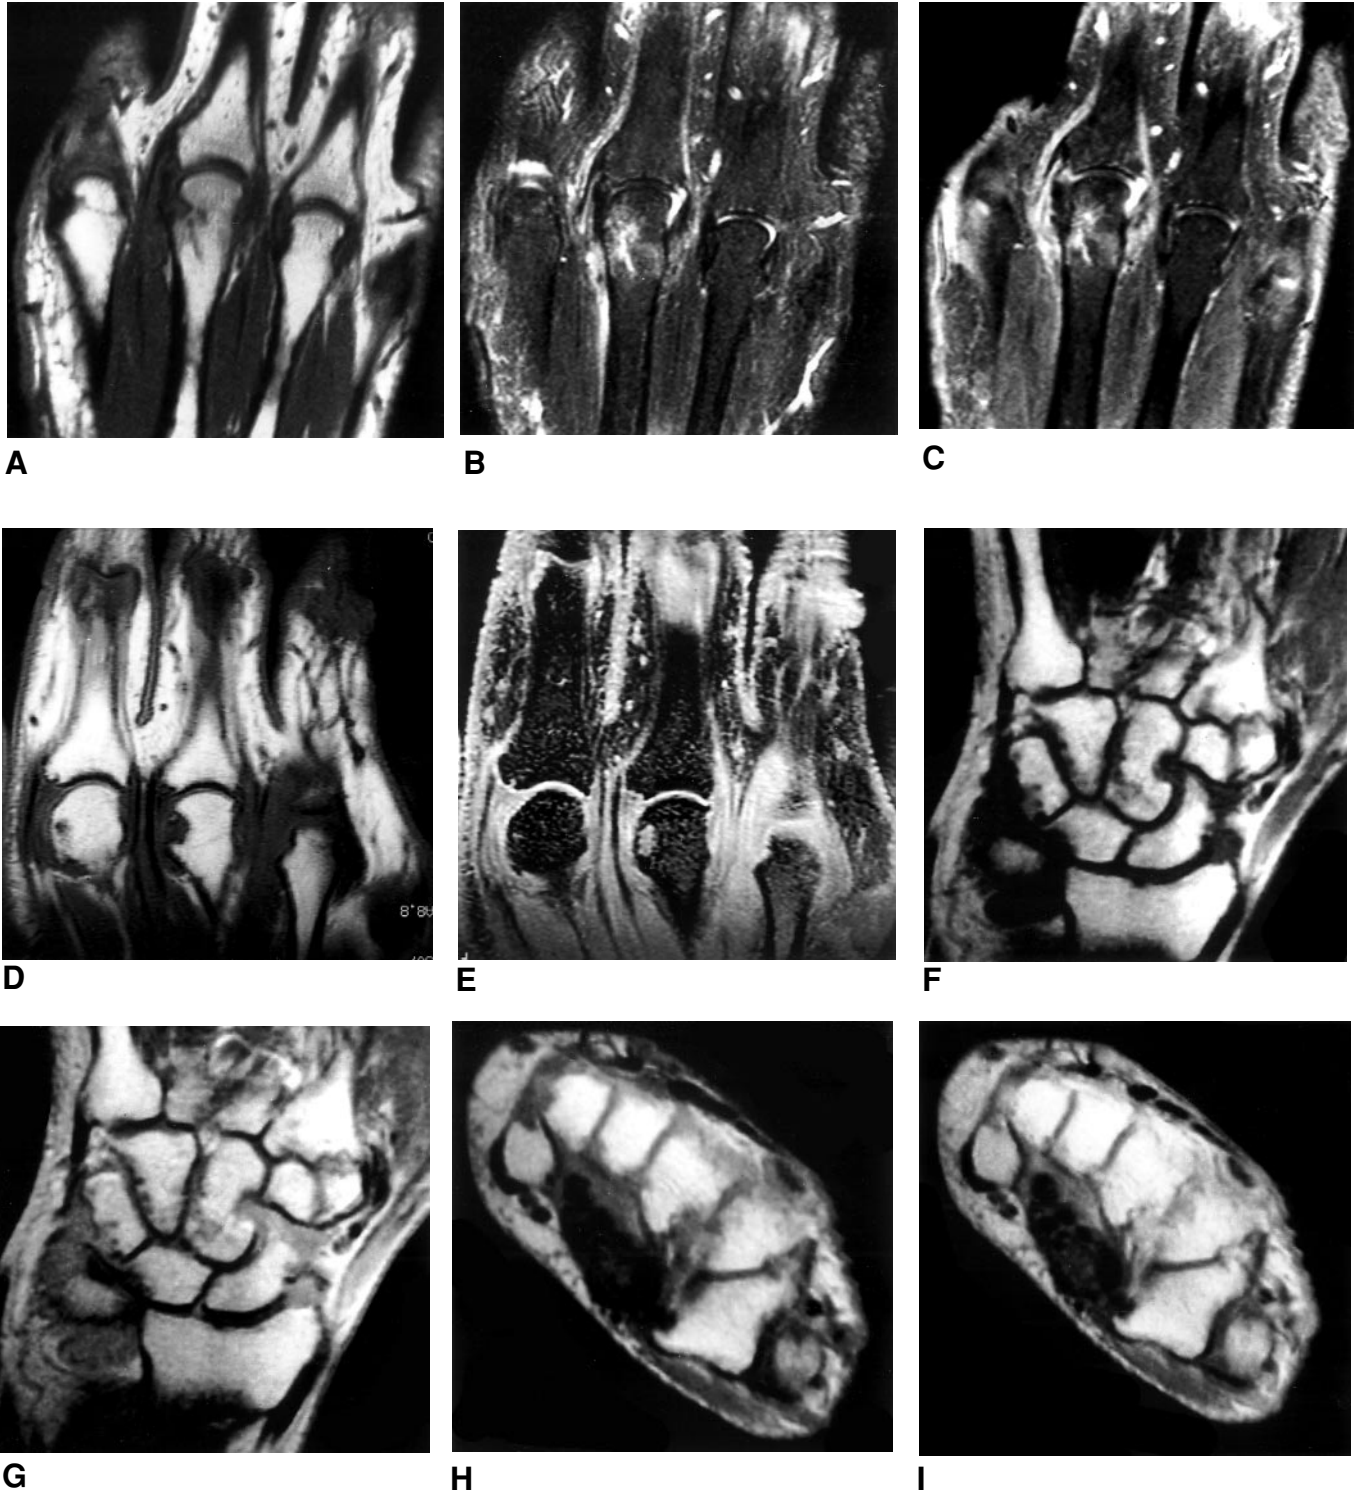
Representative examples of images by different MRI techniques. Figure A–C. Technique A (Leeds, UK): Coronal images of 3rd–4th MCP joint by (A) T1 weighted spin-echo; (B) T2 weighted fat saturated turbo spin-echo; (C) T1 weighted fat saturated after iv Gd. By centers, scores of selected variables were as follows: Bone global scores: 3rd MCP: 2, 2, 1, 2, 1; 4th MCP: 0, 0, 0, 0, 1. Synovitis global scores: 3rd MCP: 3, 3, 3, 3, 2; 4th MCP: 0, 0, 0, 1, 0. Figure D–E. Technique B (San Francisco, USA): coronal images of 2nd and 3rd MCP joint by (D) T1 weighted spin-echo; (E) T2* weighted 3-dimensional fast gradient echo. Bone global scores, 3rd MCP: 2, 2, 1, 1, 1. Synovitis global scores, 3rd MCP: 2, 3, 3, 3, 2. Joint space narrowing scores, 3rd MCP: 2, 0, 0, 0, 0. Figure F–I. Technique C (Hvidovre, DK): Coronal and axial T1 weighted spin images of the wrist before (F and H) and after (G and I) iv Gd. Bone global scores, carpus: 2, 2, 2, 2, 1. Synovitis global scores, carpus: 3, 3, 3, 2, 2.
